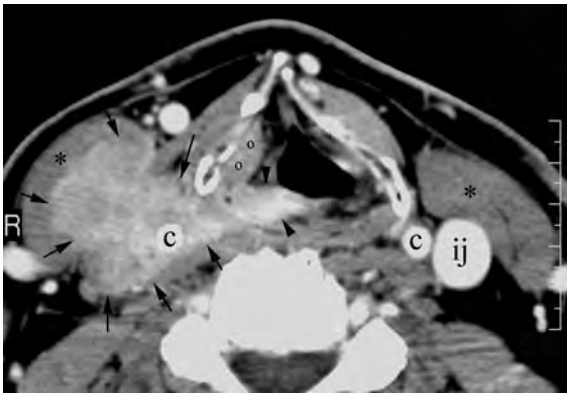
Axial contrast-enhanced CT image through the mid-thyroid cartilage level shows a large squamous cell carcinoma arising from the pyriform sinus on the *right* (*arrowheads*) with huge extension into the lateral compartment of the neck (*arrows*) causing marked flattening and lateral displacement of the sternocleidomastoid muscle (*asterisks* on *right*) when compared to its normal appearance on the *left* (*asterisks* on *left*). In addition, this mass results in complete occlusion of the internal jugular vein on the *right* when compared to the *left* side (*ij* on *left*). The common carotid artery (*c*) is also surrounded by the mass on the *right* (*c* on *right*) when compared to its normal appearance on the *left* (*c* on *left*). Please note also the submucosal involvement of the false vocal cord on the *right* (*o*)
